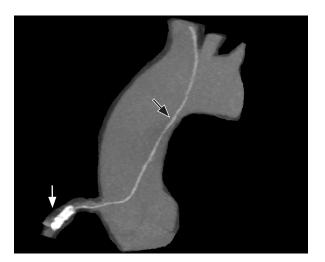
A reconstructed coronary computed tomography angiography image shows the mid-RCA stent (white arrow) with the entrapped guidewire fragment coursing cephalad (black arrow) through the aorta and brachiocephalic artery.
